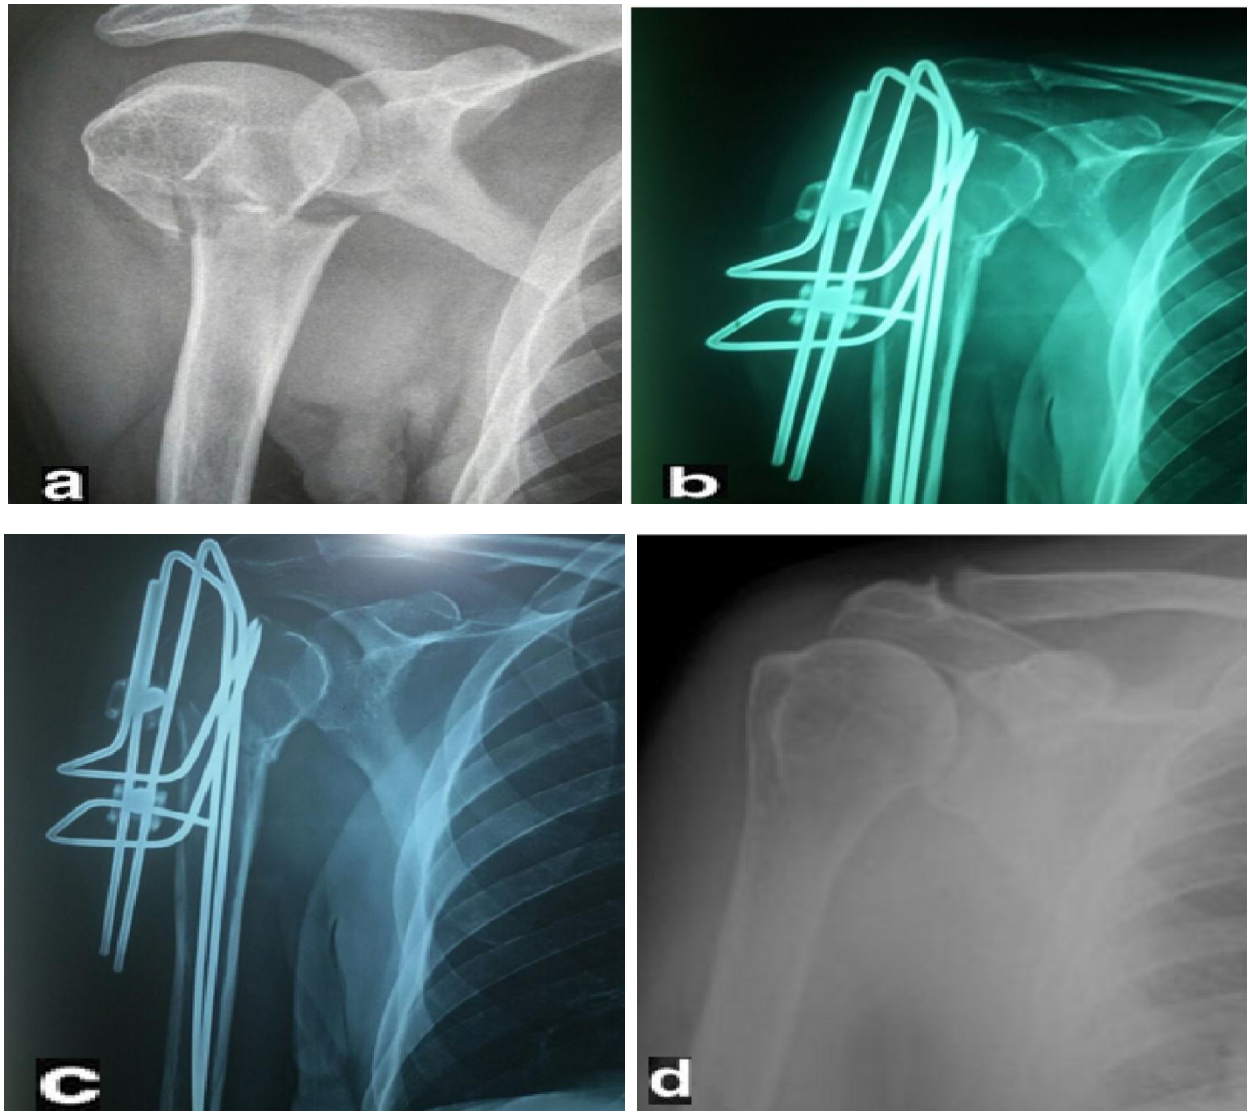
Male patient 65 years old with RT. 3-parts fracture proximal humerus, (a)Preoperative X-ray AP view, (b) Immediate postoperative AP view, (c) 6 weeks follow up, (d) 6 months follow up after removal.
